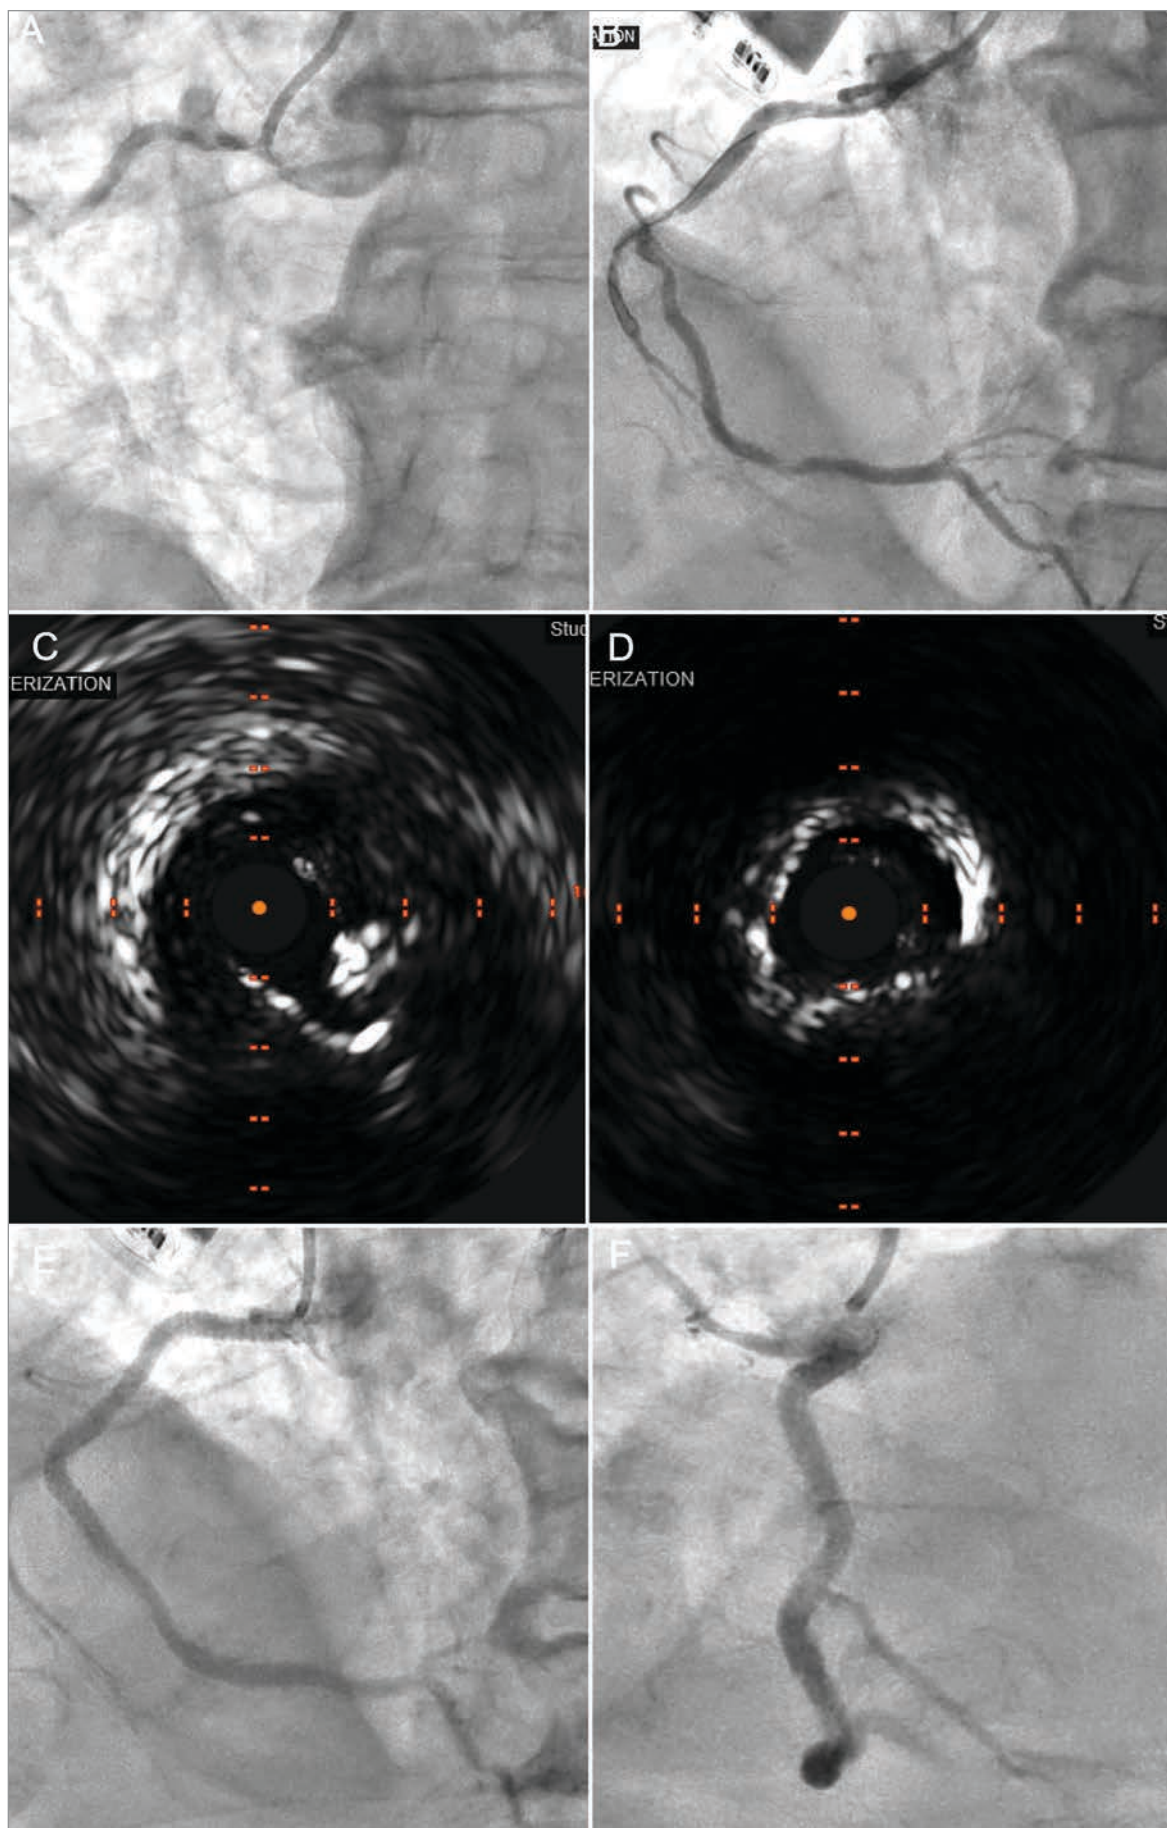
Efficacy of intravascular lithoplasty to treat aorto-ostial and proximal angulated right coronary artery (RCA) disease. (A) Baseline angiography showing a subtotal occlusion of the RCA. (B) Angiography after noncompliant balloon angioplasty of the aorto-ostial lesion, showing multiple calcific lesions in the proximal RCA as well as distal RCA. (C) Intravascular ultrasound of the mid LAD lesion. (D) Intravascular ultrasound of the aorto-ostial lesion. (E-F) Final angiography after IVL pre-treatment, and of the proximal RCA lesion and aorto-ostial lesions. Stenting was performed both distally and proximally, and at the aorto-ostial junction. The distal RCA lesion was predilated with a noncompliant balloon and responded well to this therapy. We could not advance the intravascular ultrasound at baseline through the proximal RCA lesion due to the severe calcification and tortuosity.
